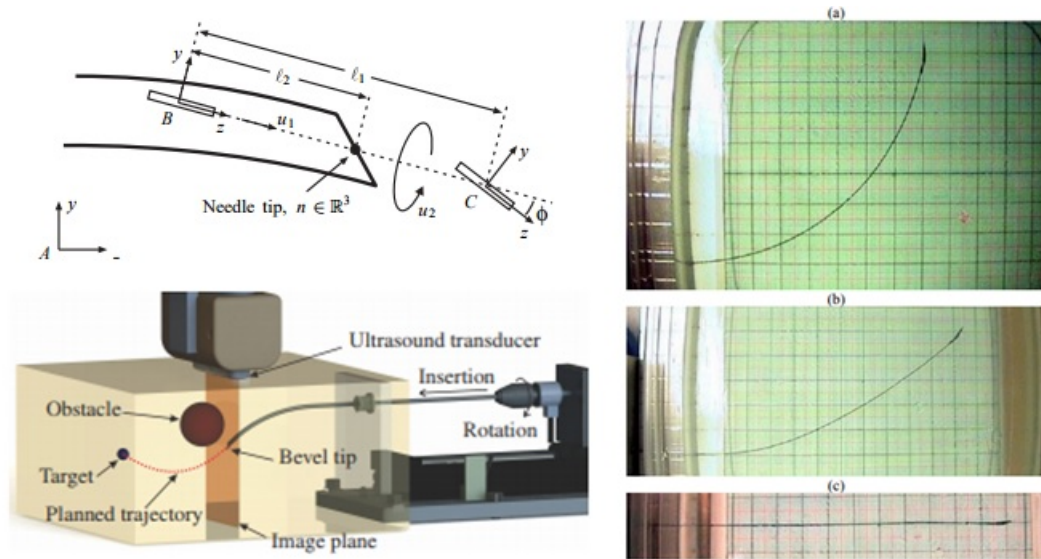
Needle steering and deflection compensation techniques in literature. Top Left) the non-holonomic bicycle model [59], Right) Three needle curvatures using the duty cycled approach [62], Bottom Left) implementation of the duty cycle approach using ultrasound for image feedback [64].
